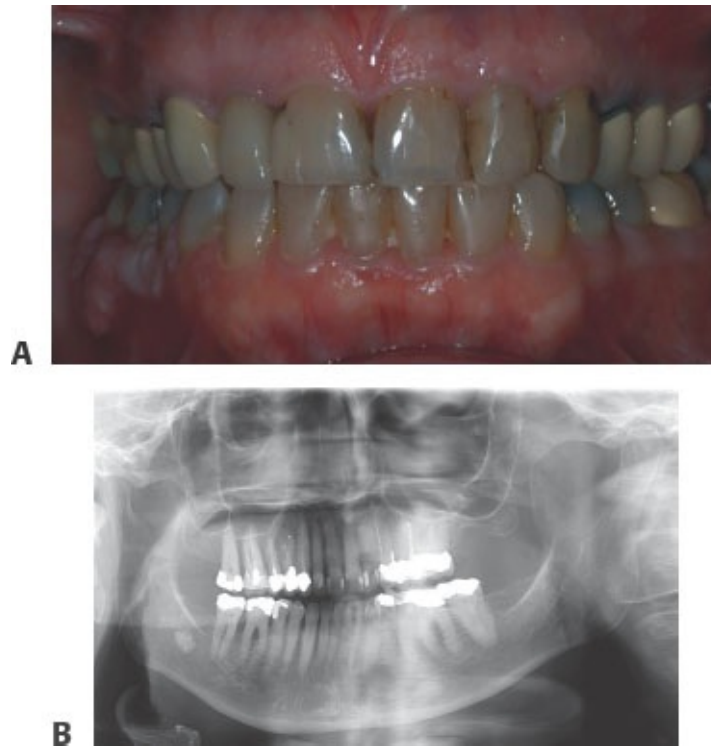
• A. Occlusion prior to mandibular resection. B. Periapical radiograph.
